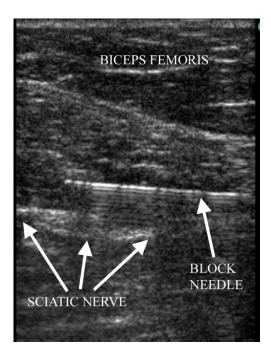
Sonogram of sciatic block in mid thigh, in plane perpendicular approach. Note the flattened ribbon like sciatic nerve in this subject.
